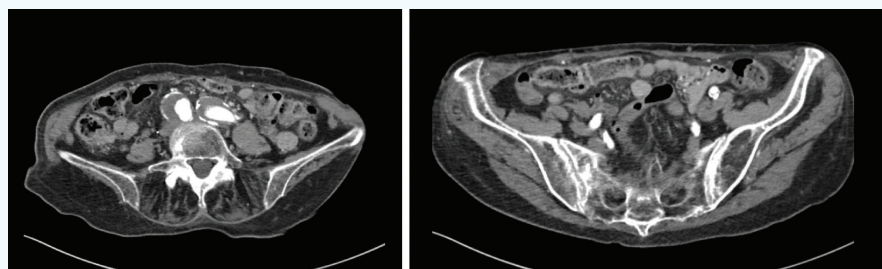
Axial CT images of the pelvis.
